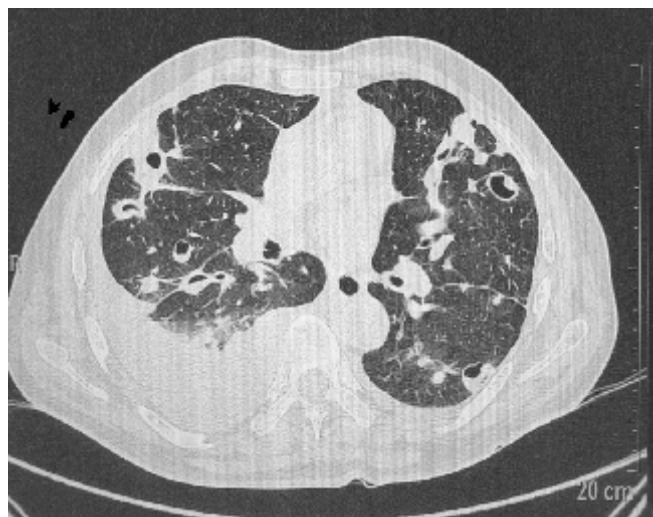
Contrast enhanced computed tomography of thorax showing bilateral cavitating nodules, few abutting the chest wall along with right pleural effusion and mediastinal lymphadenopathy
